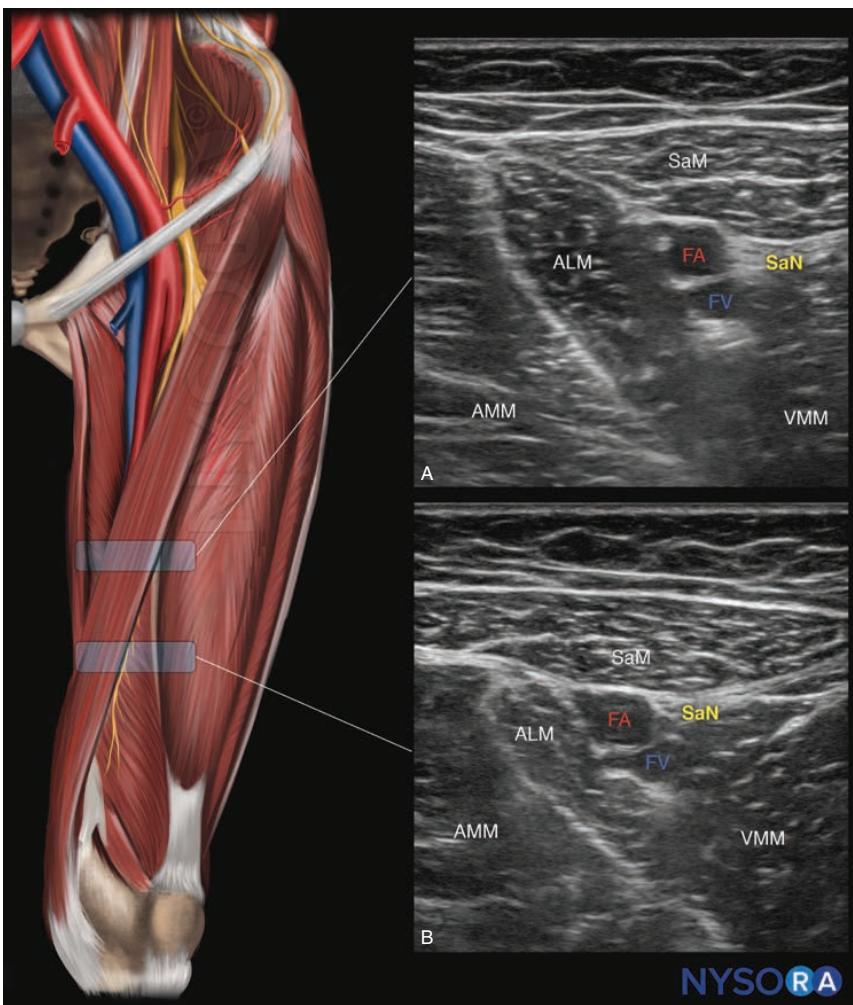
Ultrasonographic landmarks defining the distal limit of (A) the femoral triangle and (B) the adductor canal. SaM, sartorius muscle; SaN, saphenous nerve; FA, femoral artery; FV, femoral vein; VMM, vastus medialis muscle; ALM, adductor longus muscle; AMM, adductor magnus muscle.
